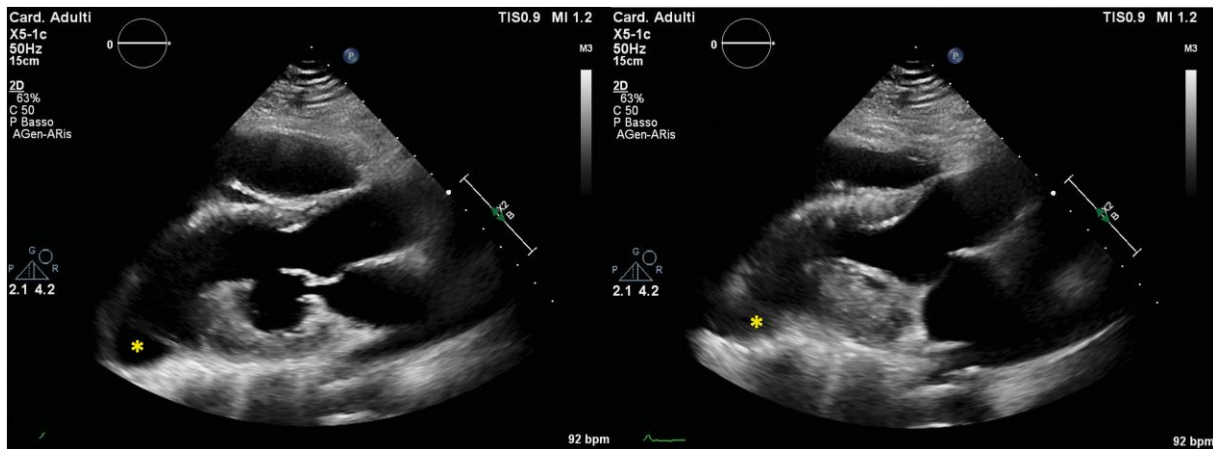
Transthoracic echocardiogram, parasternal long axis view (LAX): on the left, end-diastolic frame showing an unusual shape of the left ventricle (LV) with a sharp interruption of mid segments visualization and a bulging of the apical segments (asterisk), normally undetectable on parasternal LAX view; on the right, end-systolic frame showing a normal wall thickening of the basal and mid segments of the LV with a systolic expansion of the virtual apex (yellow asterisk).
